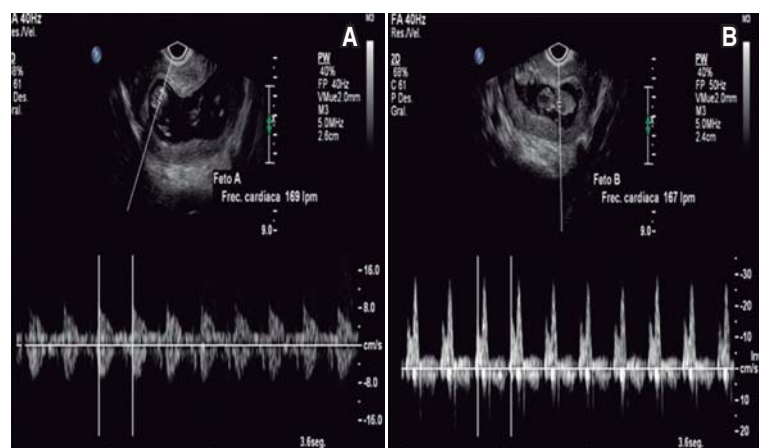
Obstetric ultrasound. A. Fetus A. Heart rate, 169 bpm. Gestational age: 11.3 weeks. Gestational sac diameter: 4.48 cm. Crown-rump length: 4.7 cm. Yolk sac diameter, 7 mm. Multiple musculoskeletal movements. No abnormalities. B. Fetus B. Heart rate, 169 bpm. Gestational age: 11.2 weeks. Gestational sac diameter: 4.0 cm. Crown-rump length: 3.7 cm. Yolk sac diameter, 7 mm. Multiple musculoskeletal movements. No abnormalities.
